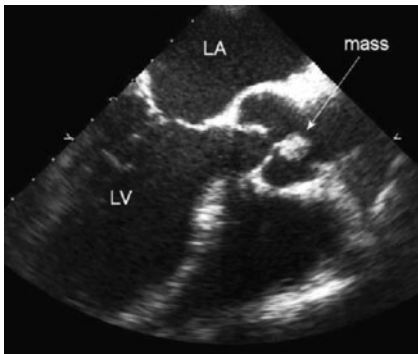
Transoesophageal echocardiography revealing a mobile fibroelastoma attached to the aortic valve. LA, left atrium, LV left ventricle.
